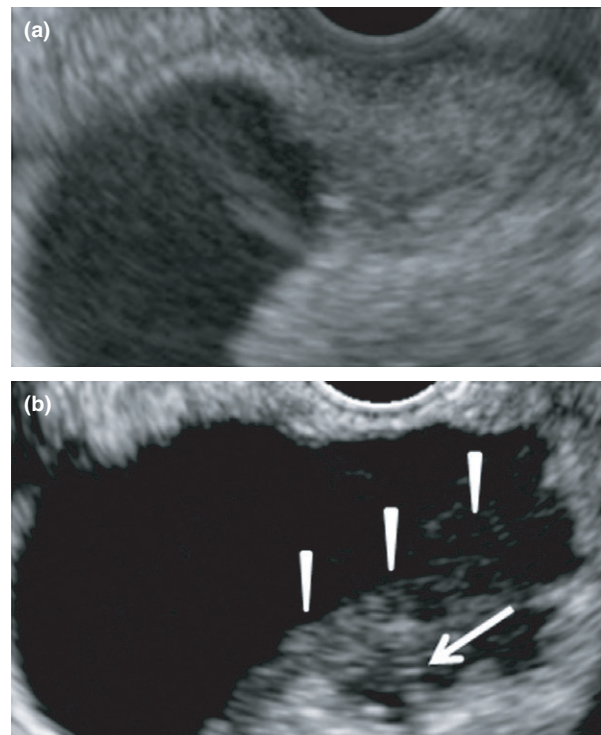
Typical case of gallbladder carcinoma. (a) Fundamental B-mode endoscopic ultrasonography (monitor mode). An echogenic structure is detected in the body of the gallbladder. (b) Contrast-enhanced harmonic endoscopic ultrasonography. The lesion (arrowheads) demonstrates irregular vessels with heterogeneous enhancement (arrow).
